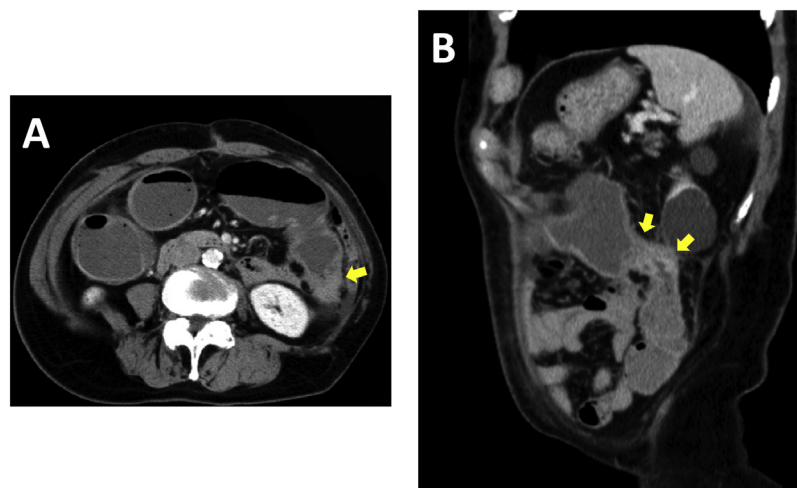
Contrast-enhanced abdominal computed tomographic scans of the abdomen obtained on re-admission, showing contrast enhancement and thickening of the intestinal wall at the anastomosis (yellow arrow) and stenosis of the anastomotic lumen. There was no evidence of findings such as abscess formation or mesenteric panniculitis around the anastomosis.
